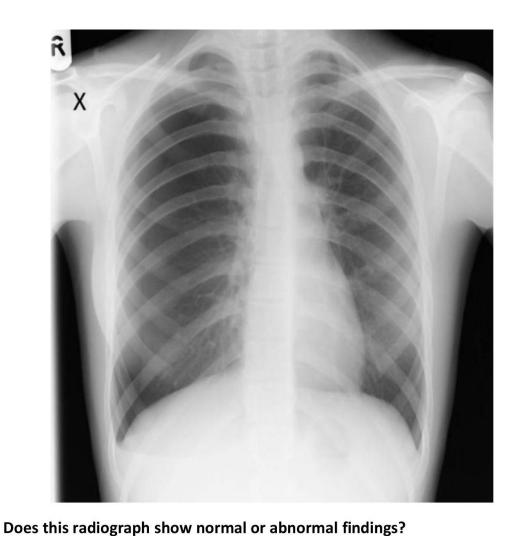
A question from the survey on pulmonary edema. CXR: chest X-ray.
